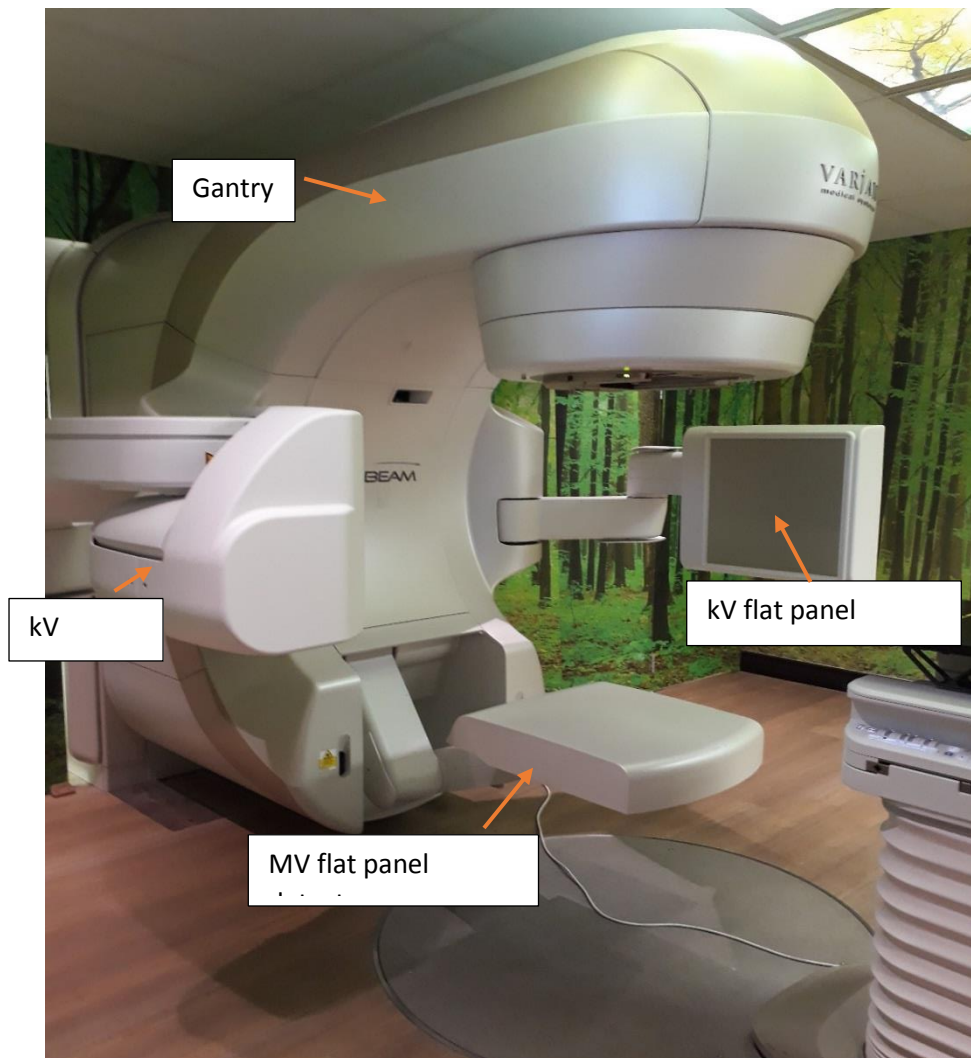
A modern Medical Linear Accelerator with kVCBCT, planar kV and MV imaging capabilities is shown.
